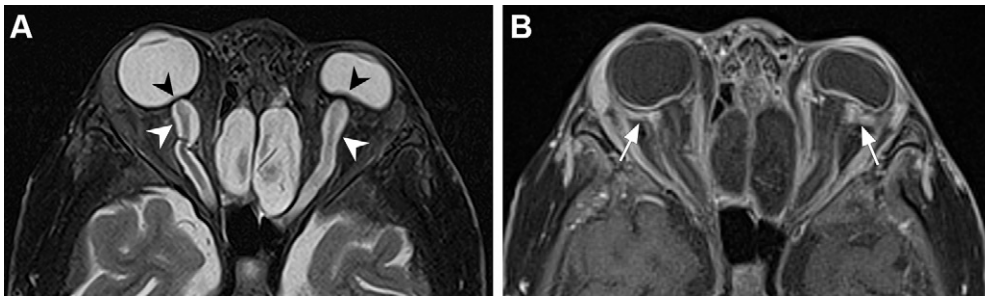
Systemic sarcoidosis in a 13-year-old adolescent boy. (A) Axial T2-weighted MR image shows scleral reverse cupping (black arrowheads) and left globe distortion. Note the enlargement of the perioptic CSF space (white arrowheads). (B) Axial postcontrast T1-weighted MR image shows contrast enhancement in the wall of the globe and postscleral fat tissue (arrows).
